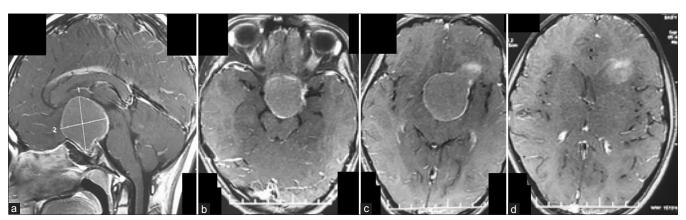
Patient 2: (a-d) Sellar, suprasellar and retrosellar craniopharyngioma seen on T1-weighted contrast sagittal MRI images
